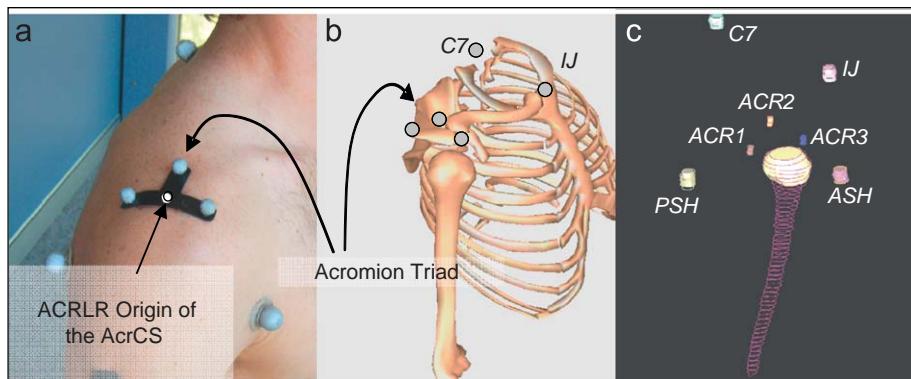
(a) The upper limb marker set required by the GHJ identification methods, (b) representation of the acromion triad on a skeleton, and (c) reconstruction of the humerus and the markers following MRI digitisation.
